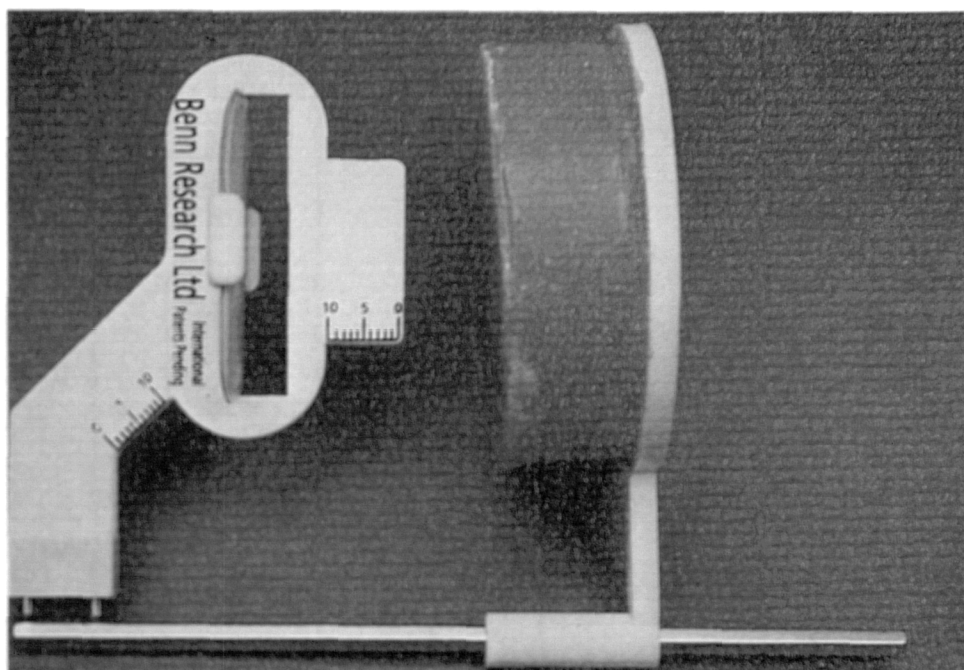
Soft tissue equivalent material attached to the aiming ring of the Benn Bitewing Film Holder.
